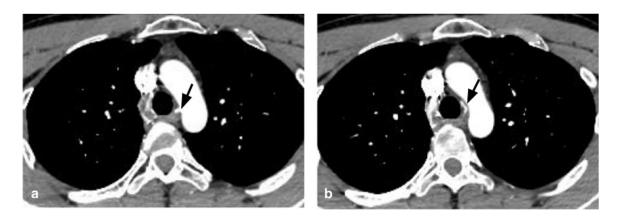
Axial CT showing the course of the aberrant bronchial artery in the tracheoesophageal groove (A) and medial to the aortic arch (B) (black arrows).
